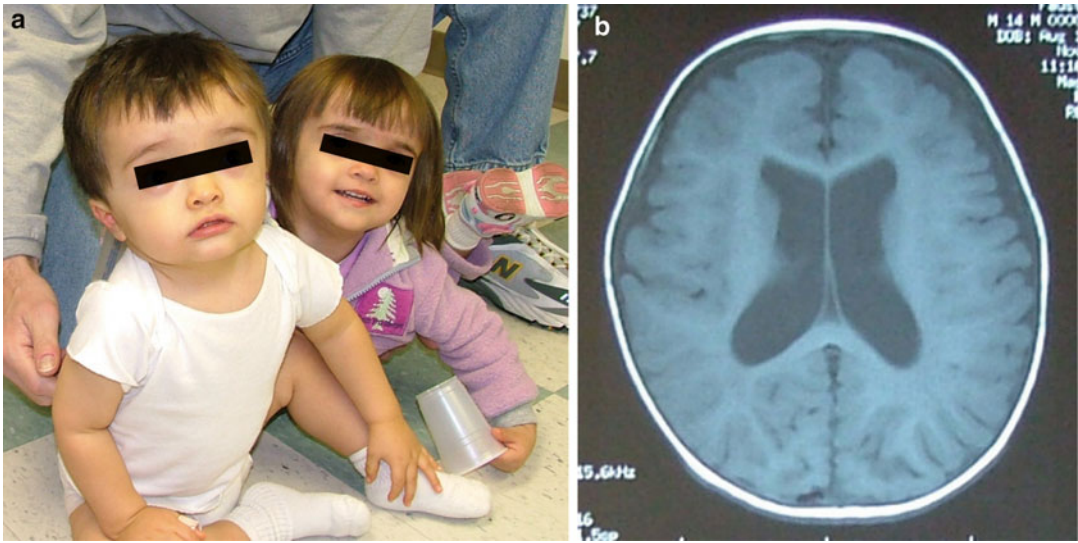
(a, b) A brother (16 months) and a sister (29 months) with benign familial hydrocephalus. An MRI of the brain of the brother showed mild ventriculomegaly
